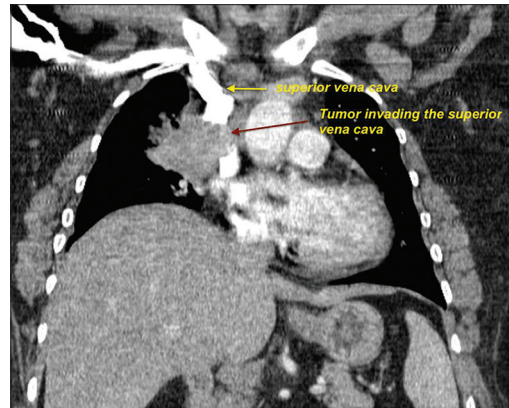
Computed tomography scan demonstrating a right suprahilar lung mass with massive mediastinal adenopathy invading the superior vena cava and right pulmonary artery
